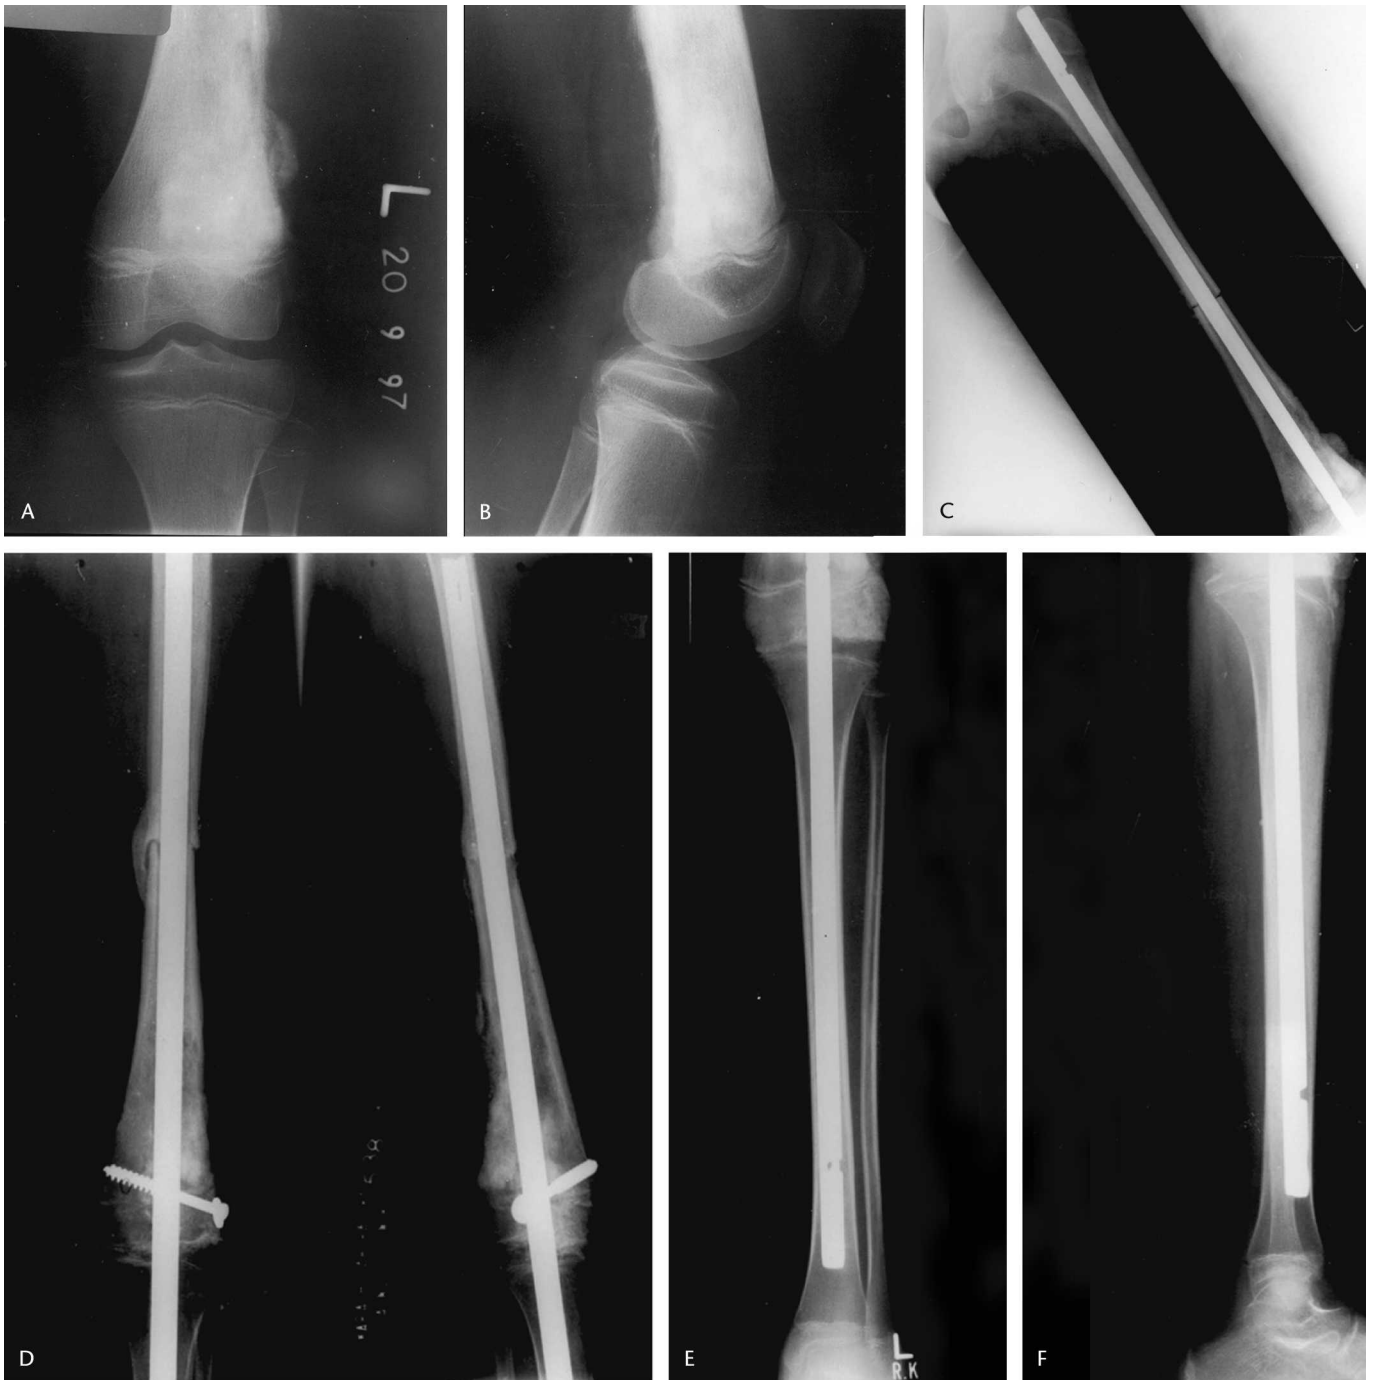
(A) An AP radiograph of an 11-year-old girl shows osteogenic sarcoma of the left distal femur. (B) A lateral radiograph shows the patient's knee. The bony structure of the femur is nicely preserved, and can be used for reconstruction after autoclaving. (C) A postoperative radiograph shows the autoclaved reimplanted segment after bone grafting and knee arthrodesis using custom-made intramedullary K nails. (D) Anteroposterior and lateral radiographs of the knee and tibia show how three-point fixation was achieved using long custom Kuntscher nails. (E) Anteroposterior and (F) lateral radiographs show the patient 2 years postoperatively. Exchange nailing was done after 6 months because of fatigue failure. The radiographs show a healed and consolidated autoclaved tumor-bearing bone at the proximal and distal osteotomy sites.
